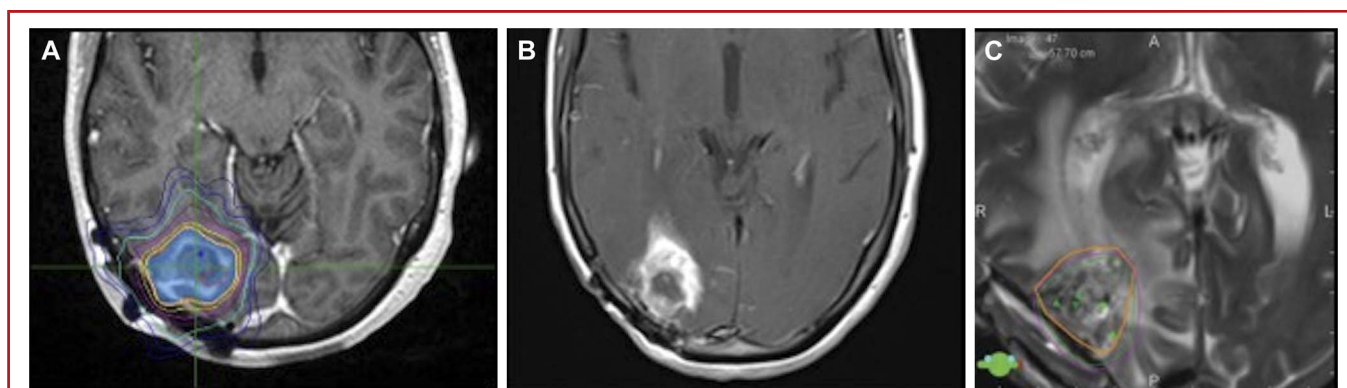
A, Initial stereotactic radiosurgery volume; B, interval MRI showing progression; and C, postresection brachytherapy volume in a single patient.
